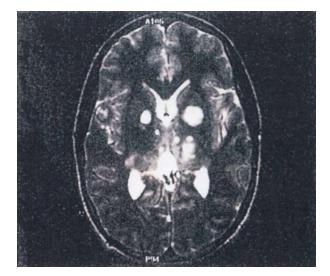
This axial T2-weighted MRI demonstrates the characteristic areas of T2 signal abnormality that are commonly detected in patients with NF1 within the basal ganglia and, occasionally, within the cerebellum and other regions of the brain. Reproduced by permission of the publisher from: Pollack IF, Mulvihill JJ. (1996) Special issues in the management of gliomas in children with neurofibromatosis. In: *Gliomas of Childhood: Current Perspectives*, Pollack IF (ed), pp. 257-268, Kluwer Academic Publishers:Boston
